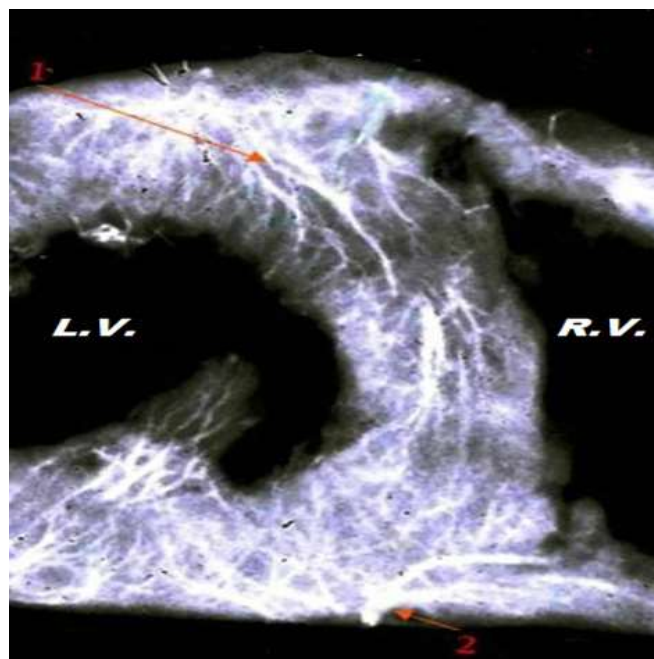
X-ray of section through interventricular septum (1- Septal ramus from anterior interventricular artery, 2 - Posterior interventricular artery with its septal rami), L.V. –left ventricle, R.V. – right ventricle.
